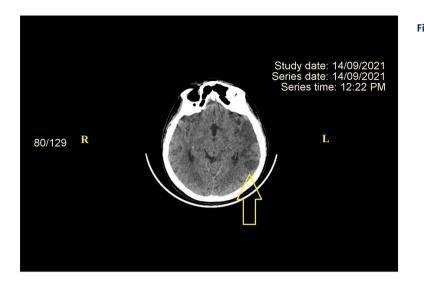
CT scan. Ischemic stroke in left superficial MCA territory (indicated by yellow arrow). The image was acquired using GE REVOLUTION EVO 128 SLICE computed tomograph produced by General Electric Healthcare Japan Corporation – Japan. CT – computed tomography; MCA – middle cerebral artery, R – right; L – left.
